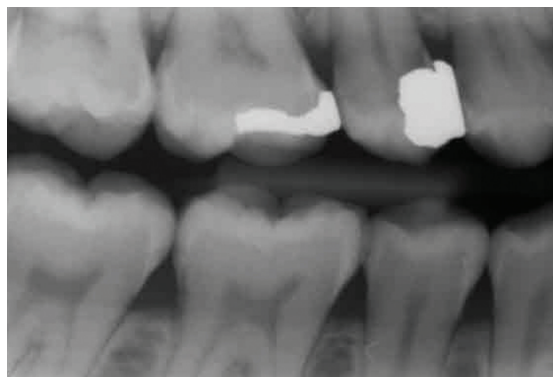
A routine X-ray revealed caries under the amalgam filling in the UR5
